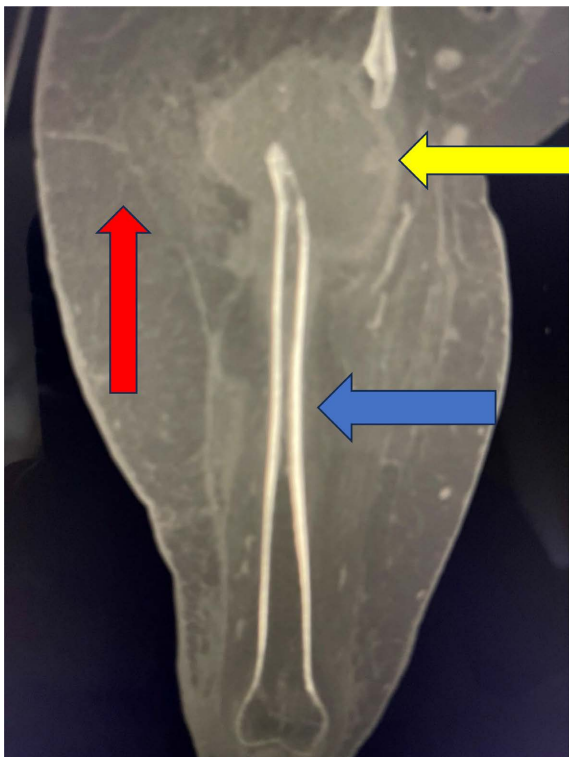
Computed tomography scan (coronal view) of the right thigh with femoral bone (blue arrow), large abscess (yellow arrow) surrounding the femoral bone, and muscle mass (red arrow).
